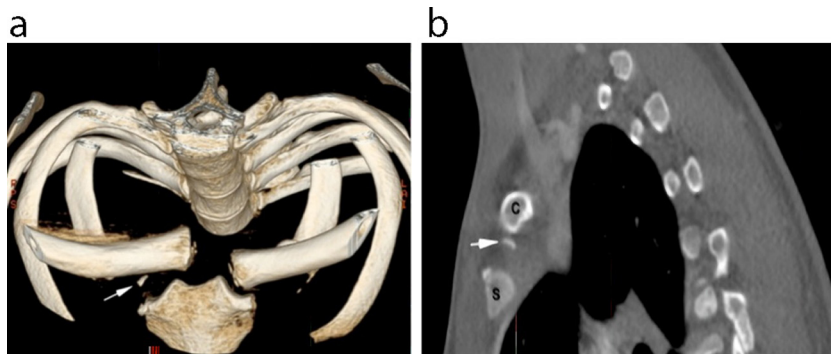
(A) Three-dimensional computer tomographic reconstruction showing complete posterior dislocation of right sternoclavicular joint with evidence of a tiny bony fragment (arrow) near the clavicle head suggesting an epiphyseal fracture. (B) Sagittal view of superior chest computed tomography (CT) scan showing posteriorly displacement of the right clavicle (C) with metaphyseal fragment (arrow). Also shown is the sternum (S).
